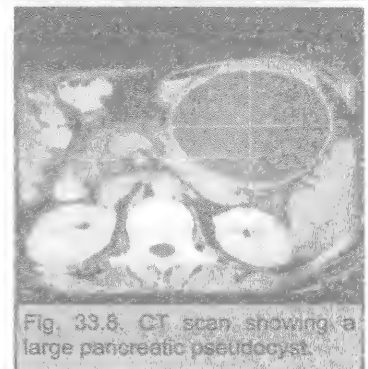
CT scan showing a large pancreatic pseudocyst.
